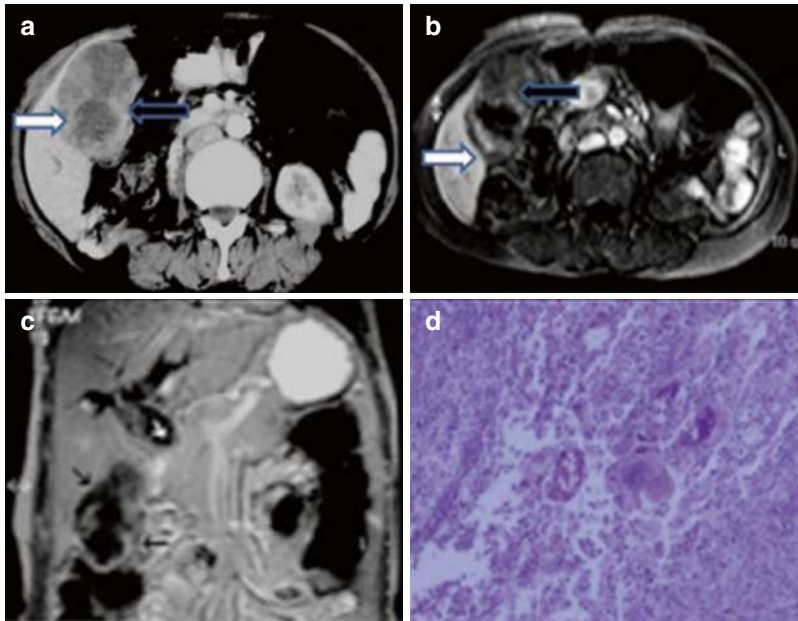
Xanthogranulomatous cholecystitis. (a) Axial contrast-enhanced CT and (b) axial post-contrast T1W MR images reveal heterogeneously enhancing lobulated gallbladder wall thickening (white arrows) with poorly enhancing intramural areas (black arrows). (c) Coronal
